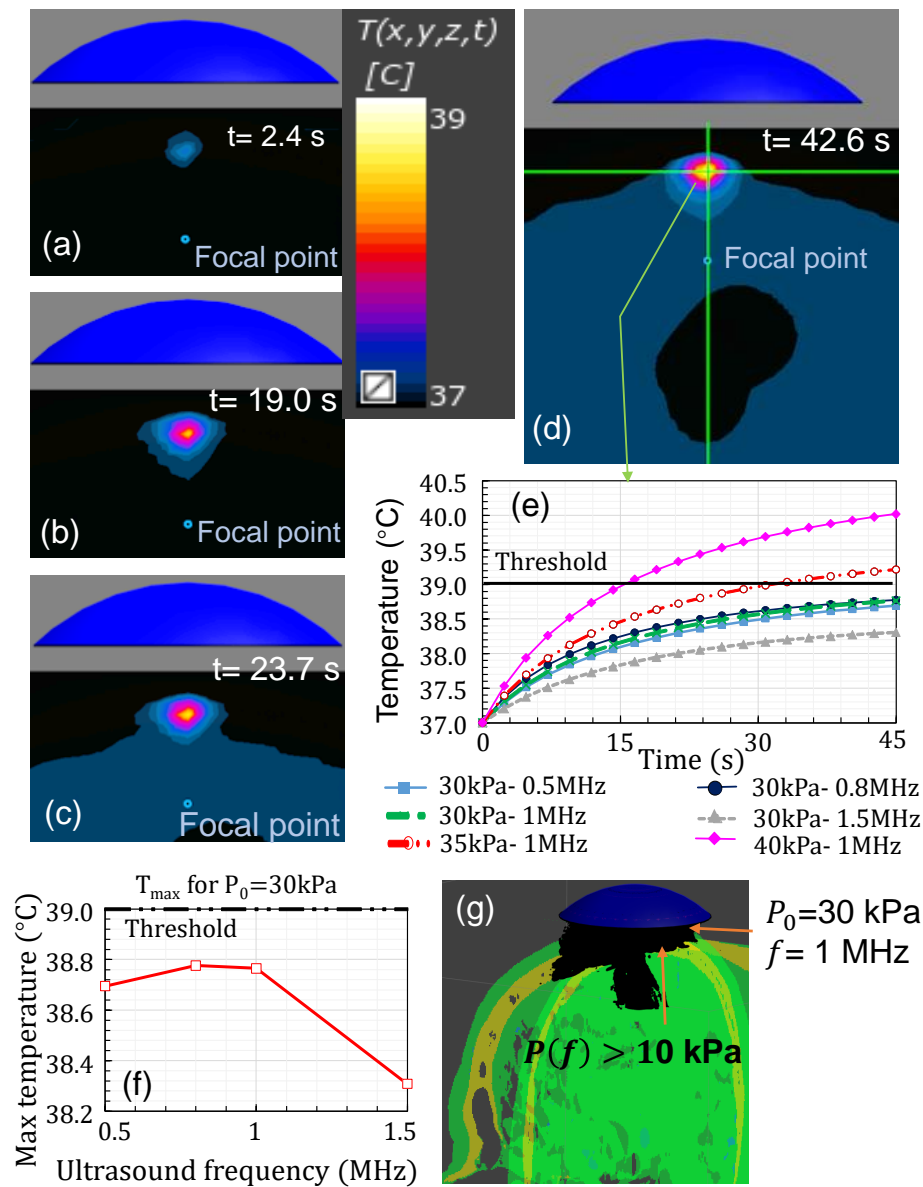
Ultrasound-thermal analysis. (a)—(d) The transient temperature contours over time with $P_0 = 30$ kPa and $f = 1$ MHz, (e) temperature at the top of the skull over time for different acoustic settings, (f) maximum temperature versus ultrasound frequency, and (g) The steady-state iso-volume pressure > 10 kPa inside the brain.
